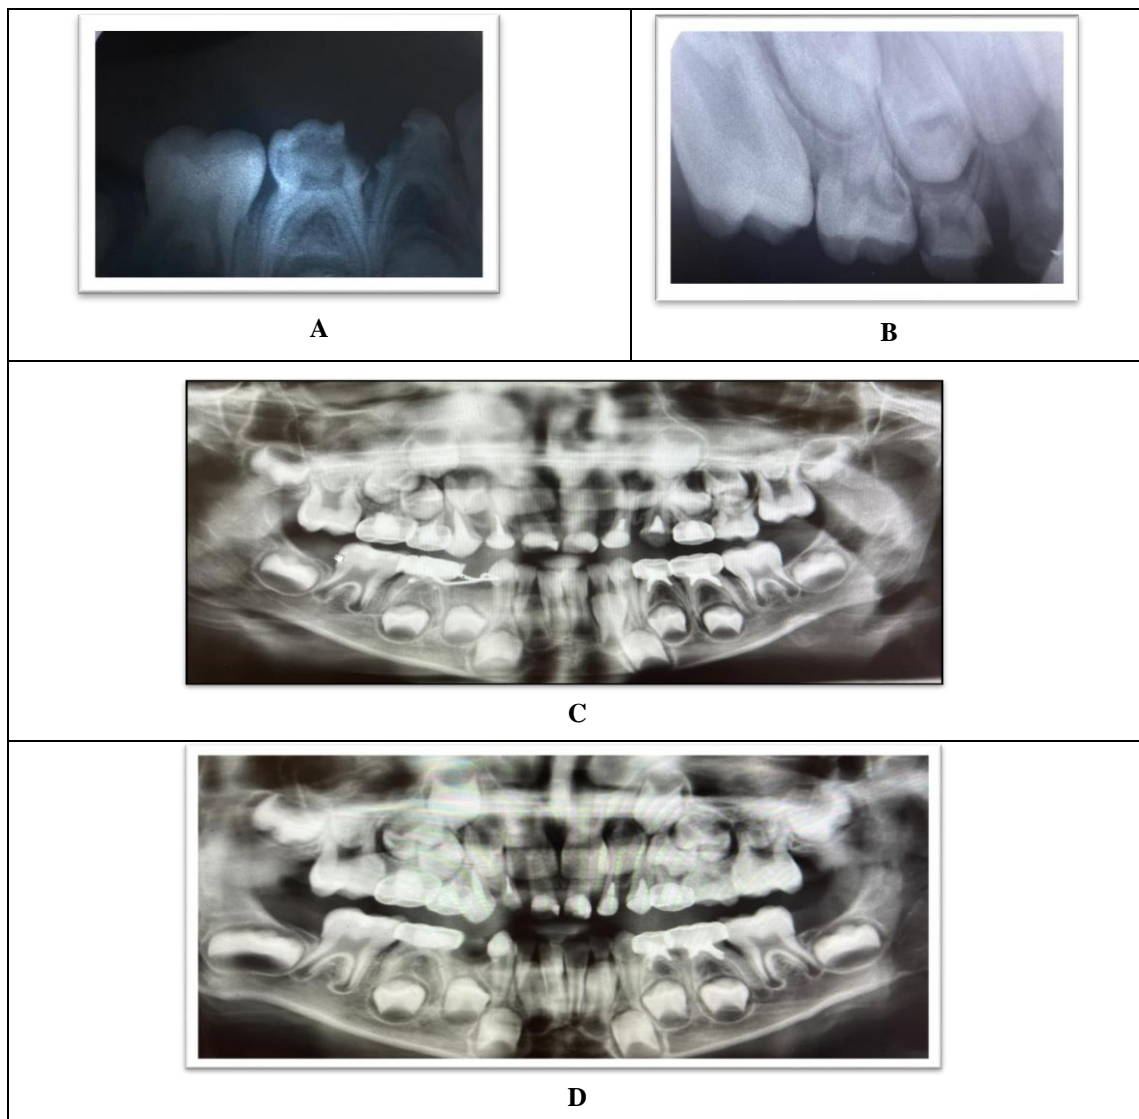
(A, B): X-ray before pulpectomy treatment (C): Panoramic view after full mouth treatment using diode laser (D): Panoramic view after 3 months follows up using diode laser.
